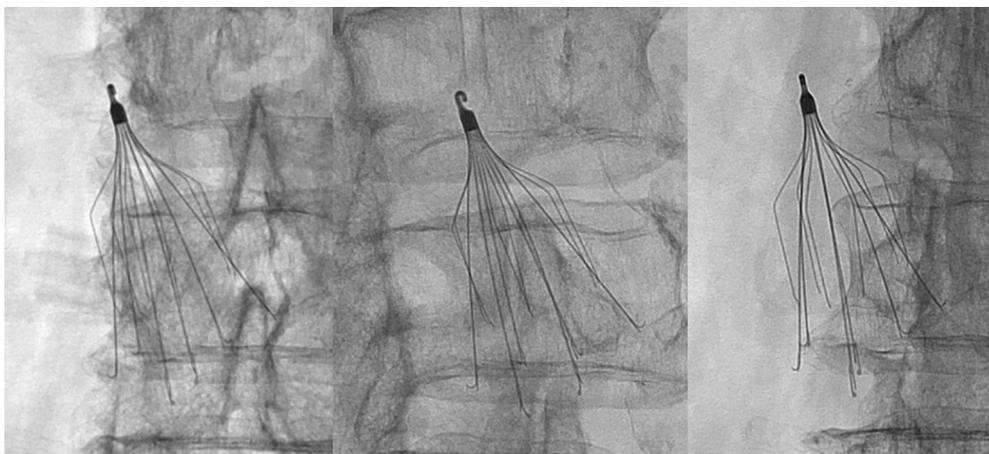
High-resolution frontal and 2 oblique (right anterior oblique and left anterior oblique at 45°) magnification spot radiographs obtained with the fluoroscopic unit demonstrate an intact, mildly angulated Denali IVC filter.
